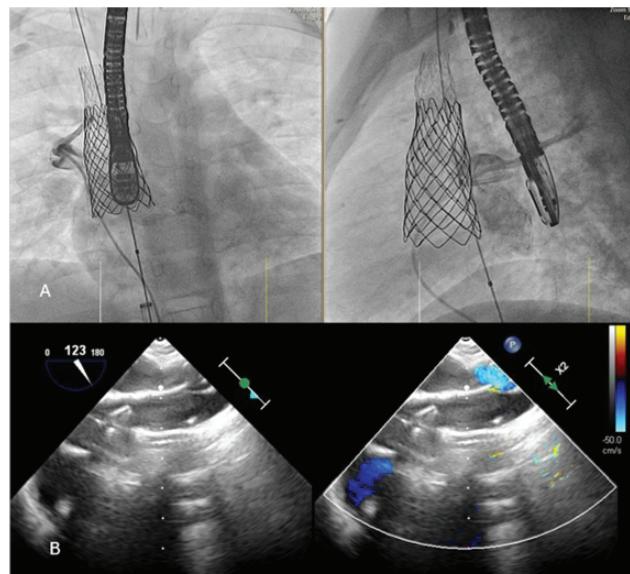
A Angiogram in the RUPV showing successful redirection of pulmonary venous flow to the LA. B Color Doppler TEE showing no residual sinus venosus shunt.
